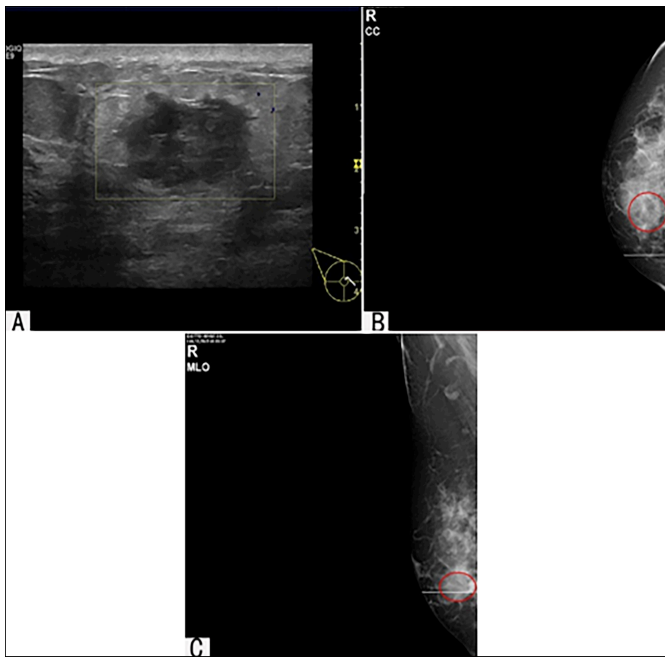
(A) Ultrasound of the right breast: A hypoechoic nodule with an echolethic dark area visible within. (B and C) Mammogram of the right breast: Right CC-view and MLO-view showing a tissue mass (circle) in the right breast.
